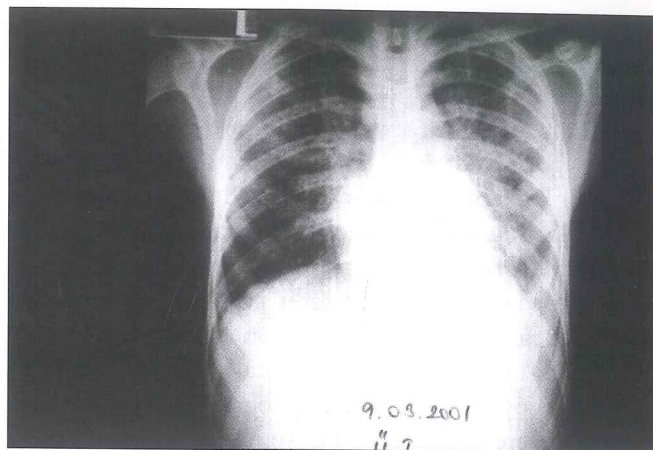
Chest x-ray on second hospital day demonstrating a marked decrease in alveolar opacities.
